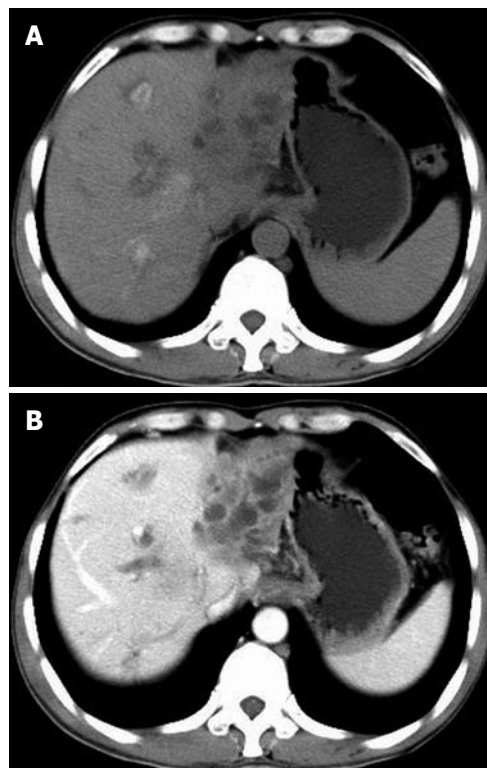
A 54-year-old male with liver malignant fibrous histiocytoma. A: Non-contrast computed tomography shows ill defined lesion of density 30 HU in the left lobe with dilated intrahepatic biliary duct; B: Contrast scan portal vein phase shows low enhancement compared to normal liver parenchyma and multiple areas of low attenuation.
